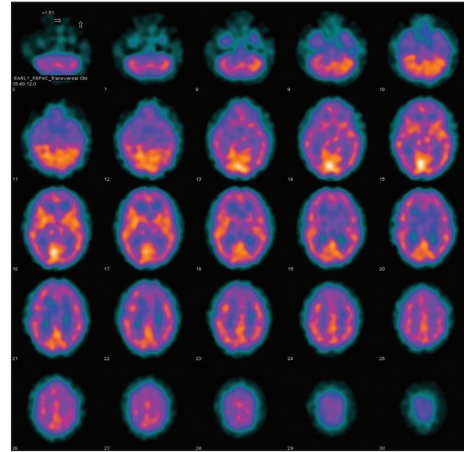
On selected transaxial brain single-photon emission computed tomography images, a comparative improvement of perfusion respect from the previous study is shown; although, small perfusion defects in brain cortex are still present
